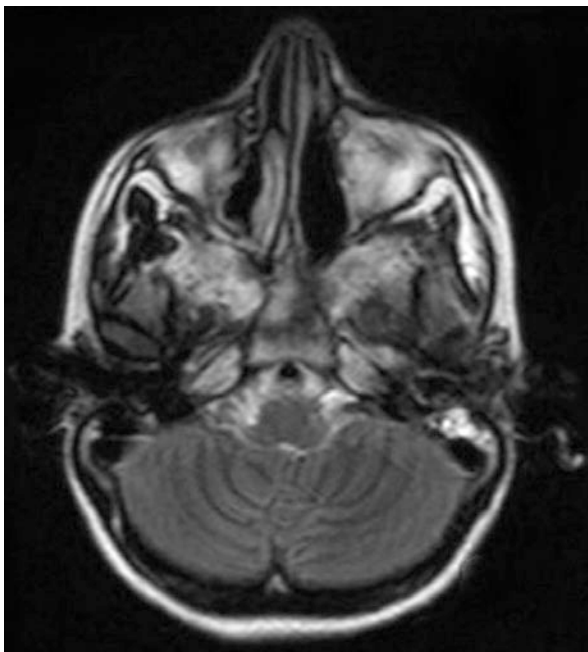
CT scan of the brain. Rhino-orbito-cerebral mucormycosis
